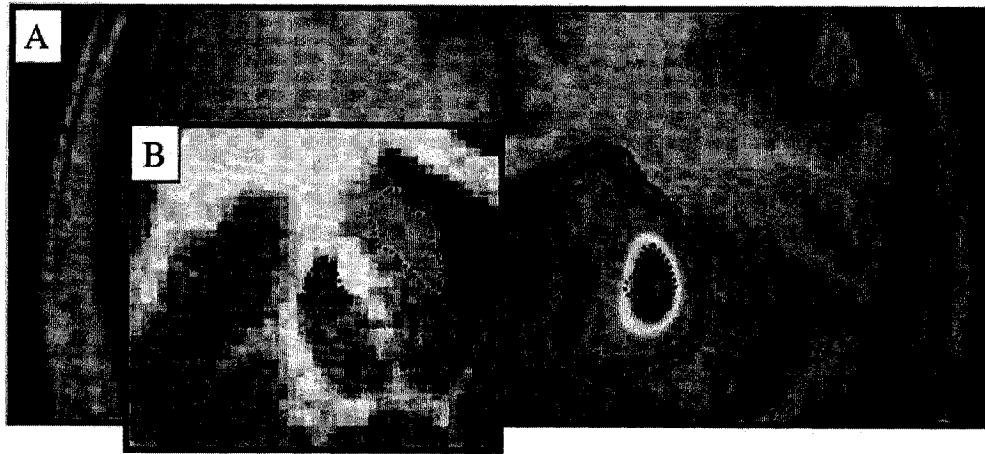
One subject's [^{11}C]raclopride binding potential map (right striatum) for the first scan day transformed to Talairach space and overlaid on his MRI in Talairach space. Regions of interest drawn on the same subject's MRI (left striatum) in Talairach space. *Red*: Ventral Striatum / Nucleus Accumbens (z: 8 to 4), *Blue*: Putamen (z: 2 to 10), *Green*: Caudate (z: 2 to 15).
